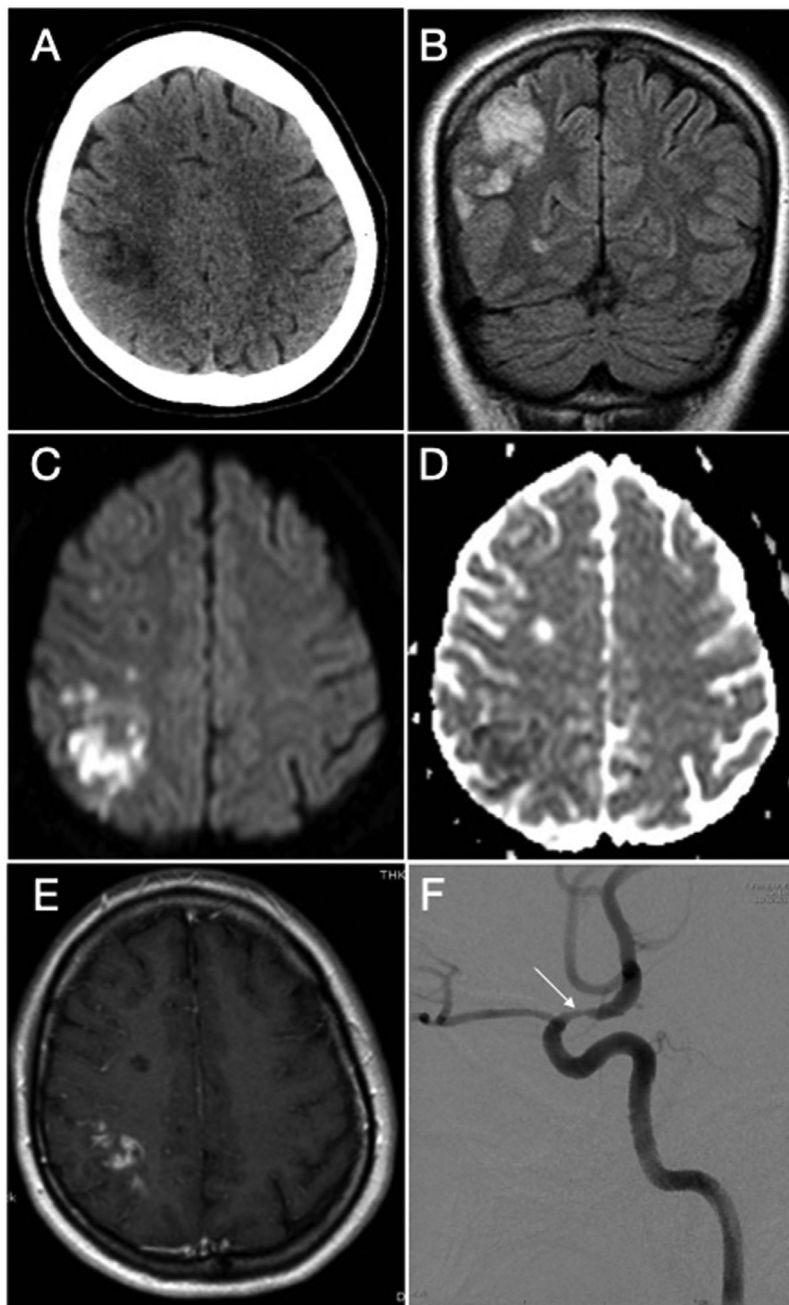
Brain computed tomography (1A) showed a recent right-sided parietal ischemia. MRI revealed ischemic lesions within the same vascular territory at different stages on FLAIR (1B) and DWI (1C) sequences. Cerebral angiography (1D) confirmed the isolated focal arteriopathy and ruled out any other arterial involvement.
